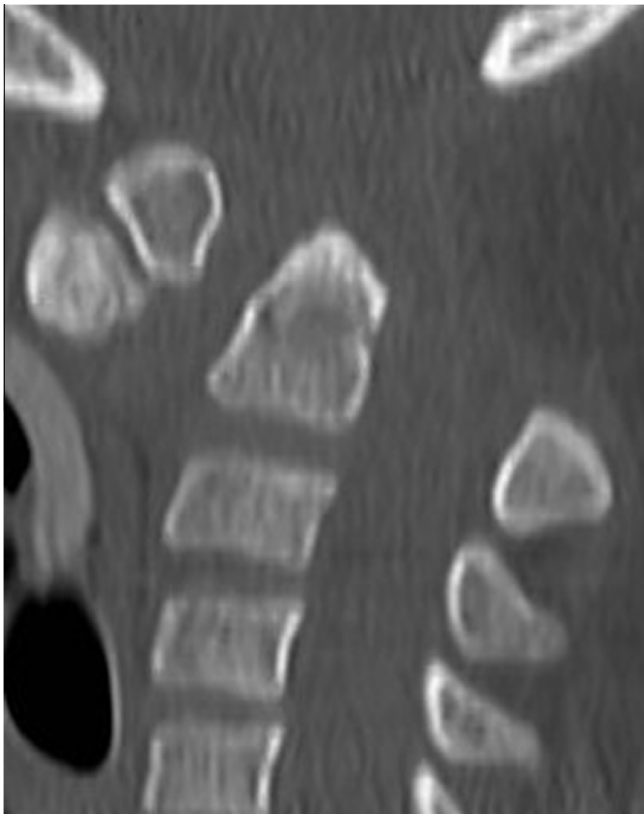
Spinal sagittal CT scan shows complete anterior translation of the C1 arch and upper portion of the odontoid in front of the base of C2.
